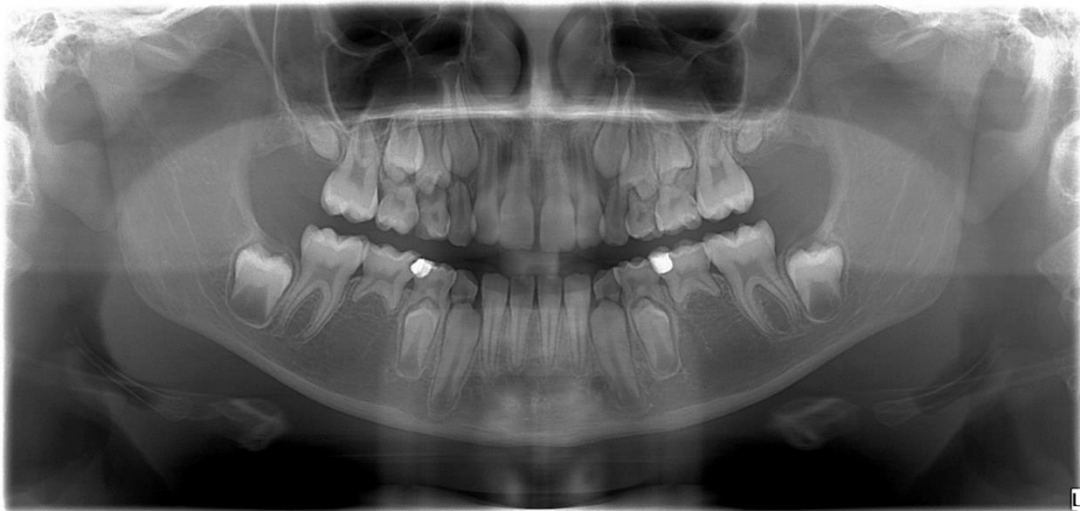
Case 4 radiography (Agenesis of 18, 28, 35, 38, 45 and 48 and microdontia of teeth 17 and 27)
